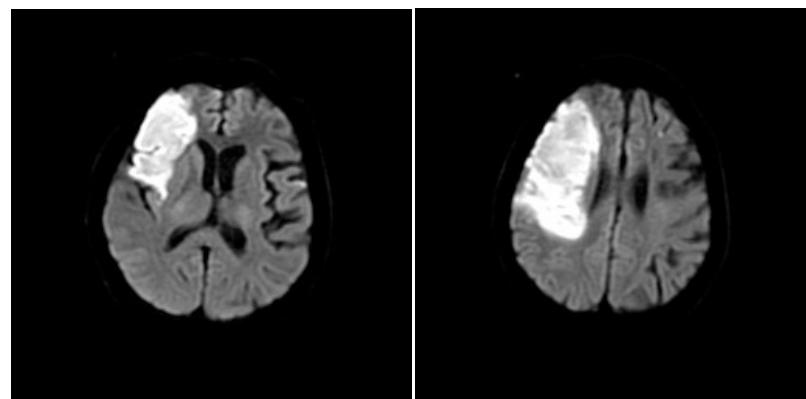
MRI-DWI brain image shows restriction in M1, M2, M4 and M5 area as per ASPECT distribution in MCA artery distribution in a patient of hemiparesis
